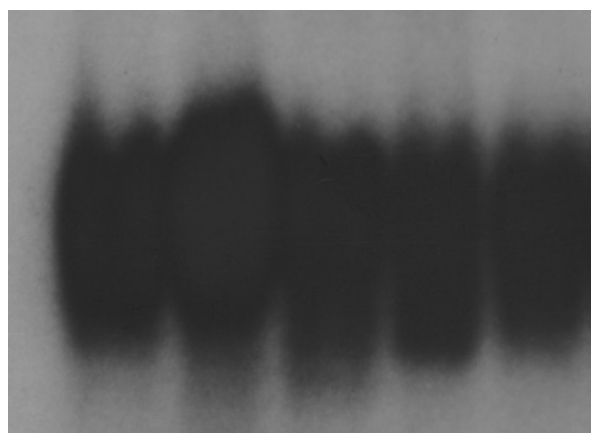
Representative radiographs of NF-kappaB activation in PBMCs of patients with acute pancreatitis. Lanes 1-5.
